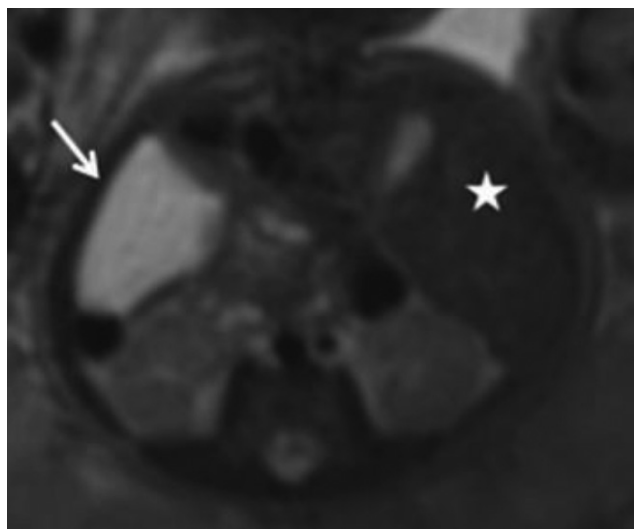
On axial T2-weighted foetal imaging shows hyperintense cystic lesion on the left side (arrow), note that liver is on the right side (star)
